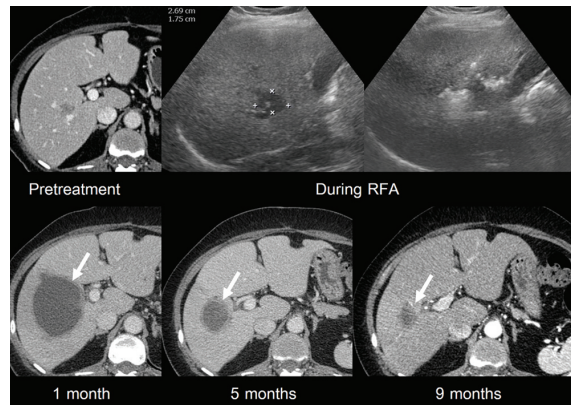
A 68-year-old woman with colonic cancer and liver metastasis underwent RFA. Follow-up CT scan at 1 month after the procedure revealed complete ablation zone with large biloma (arrow). She had no clinical symptom. Follow-up CT scan at 5 and 9 months showed spontaneous resolving of the biloma.
